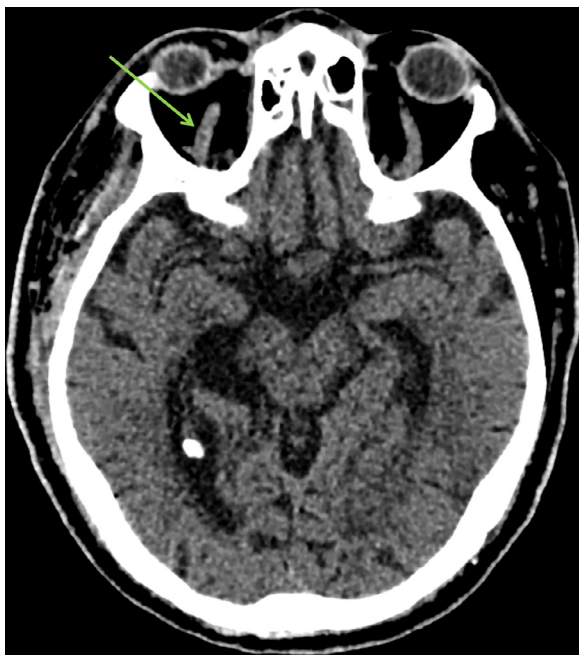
Axial CT head slice demonstrating complete resolution of the asymmetrical right SOV hyperdense thrombus (green arrow) following 3 weeks of anticoagulation with LMWH.
